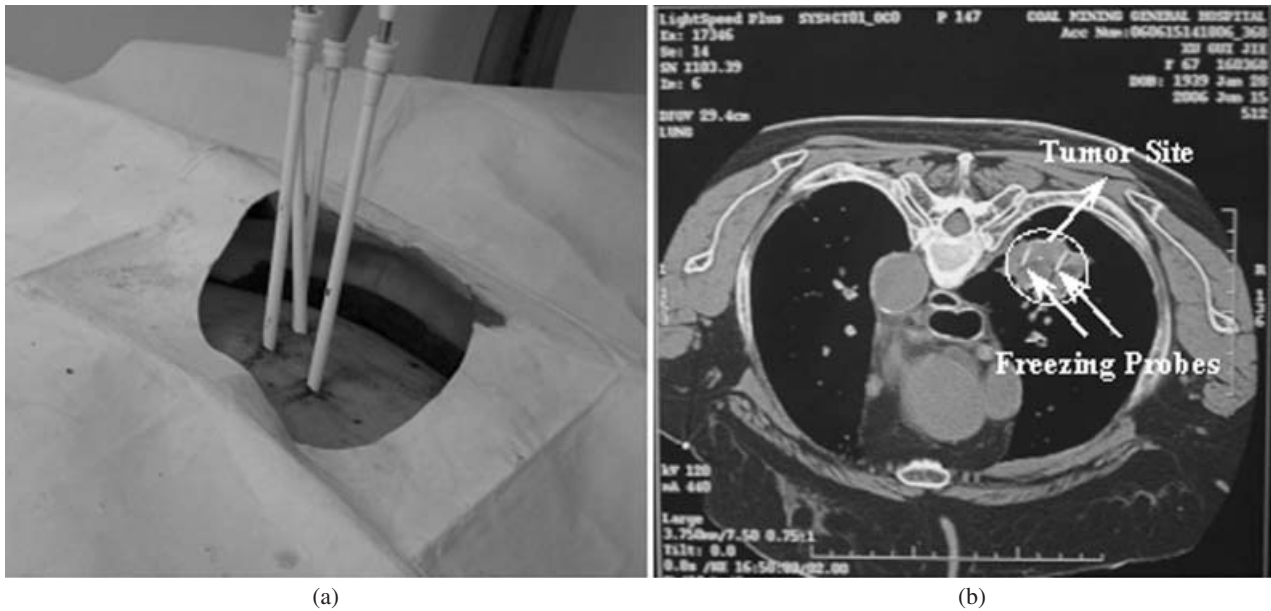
Optical and CT pictures of the cryosurgical procedure for case 1; (a) cryosurgical incision, (b) intraoperative CT during cryosurgery.
